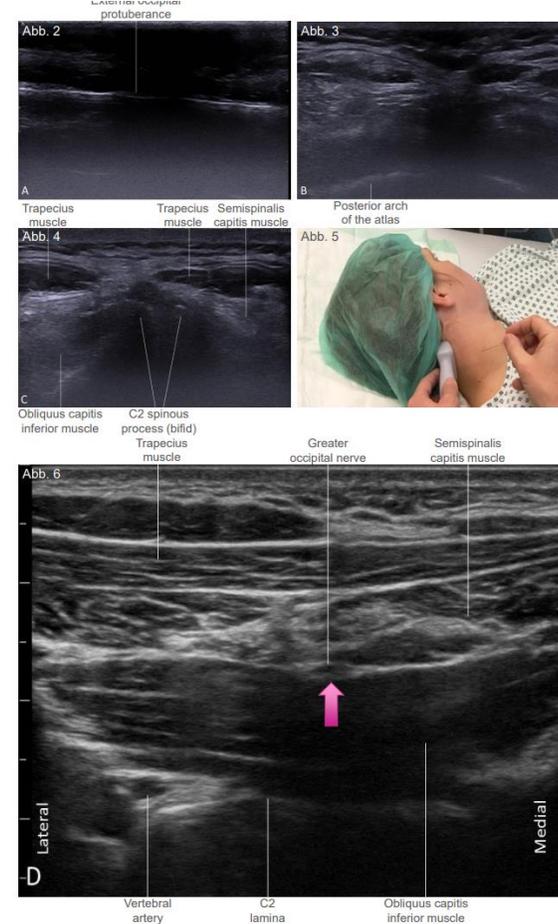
Sonographie bei der proximalen Technik (A-C) zum systematischen Auffinden des N. occipitalis major. Abb. 5: Sondenposition bei der proximalen Technik. © M. Greher
